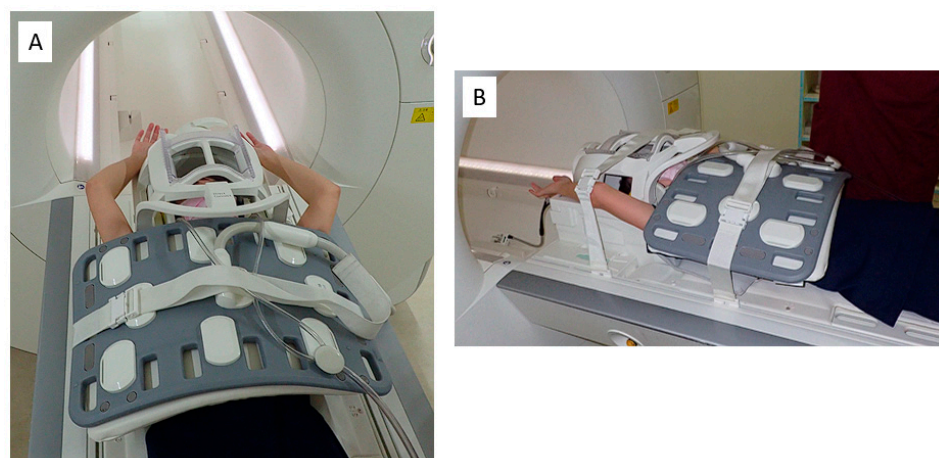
MRI imaging limb position. (A) The patient is placed in a supine position with the upper limb further elevated than in the Wright test position. (B) The upper extremities from the trunk are secured. MRI, magnetic resonance imaging.
